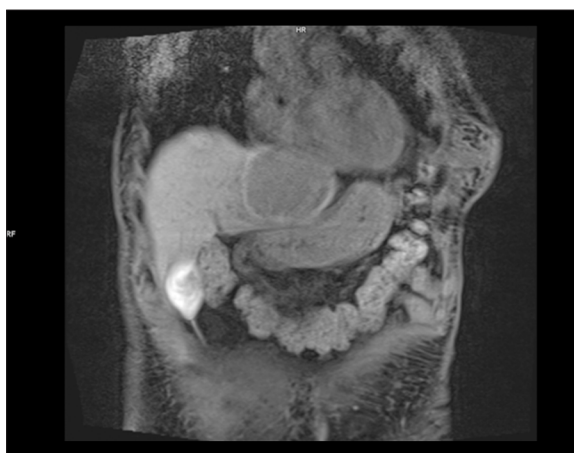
T1-weighted fat-saturated coronal image acquired 40 minutes post intravenous contrast injection, revealing fistula with the internal opening in the fundus of the gall bladder.
